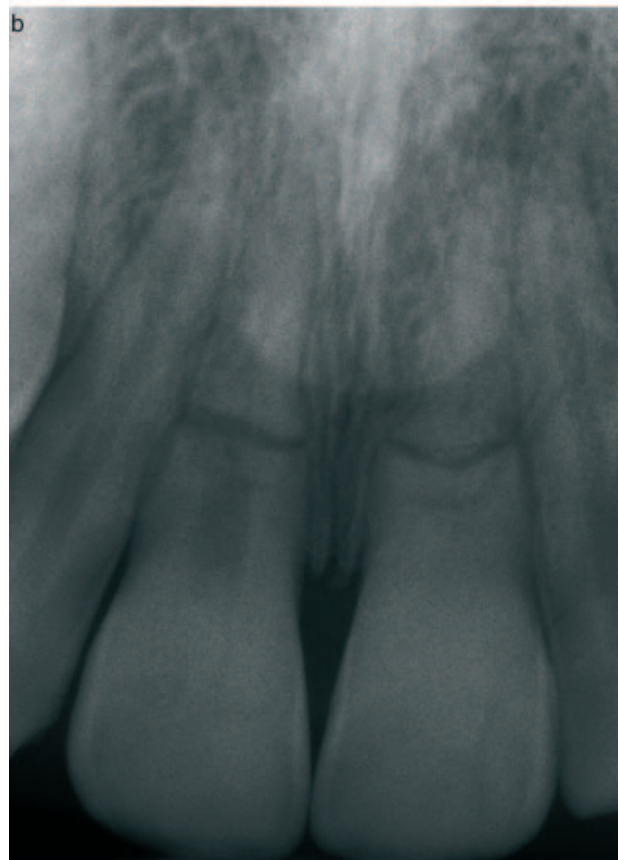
Healed root fractured teeth in risk of extraction. A 12-year-old boy visited a dentist for the first time. All the teeth were examined radiographically, including the maxillary central incisors, which, according to his mother, had been injured 3 years earlier in an accident. The teeth were asymptomatic, functional and acceptable in appearance, yet both the examining dentist and a subsequent consulting oral and maxillofacial surgeon recommended extraction of both teeth based on the radiographic appearance. Fortunately for the boy, his mother sought additional consultation and was advised by a dentist more familiar with dental trauma that neither tooth should be extracted. (a) The photographs show central incisors. (b) The radiograph indicates that the root fractures have healed satisfactorily.
